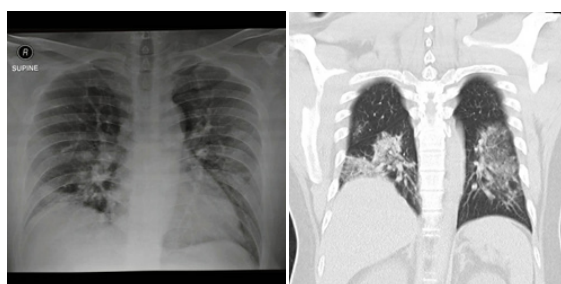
Radiological findings of the second patient. (a). CXR, bilateral ground-opacity in the peripheral section of the lungs, suggestive of pneumonia; (b). Chest CT (coronal), bilateral peripheral ground-glass opacity and multiple consolidated areas with interlobular septal thickening.
